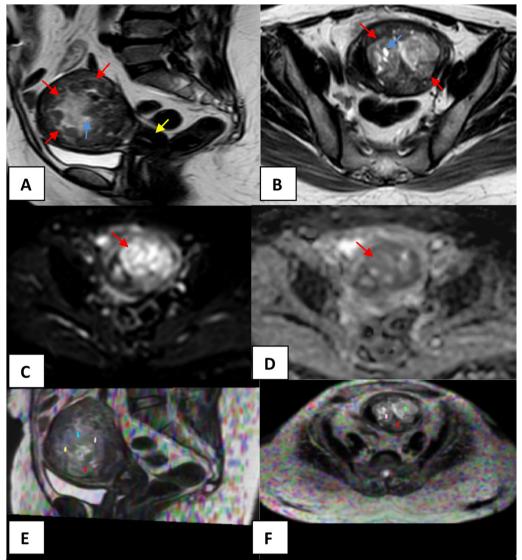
A 51-year-old postmenopausal female presented by menorrhagia and pelvic pain. A, B *Sagittal and axial T2 WIs* occupation of the endometrial cavity by a poorly defined large oval-shaped polypoidal soft-tissue mass displaying heterogeneous SI and infiltrating the uterine body (red arrow). The mass has foci of high SI due to necrosis (blue arrow). No cervical extension (red arrow). C *Axial DWI with b value of 1000 s/mm*² high SI of the endometrial soft-tissue mass (yellow arrow). D *Axial DW-ADC map image* low signal intensity of the endometrial soft-tissue mass (red arrow). Mean DW-ADC value of the mass = 0.898×10^{-3} mm²/s. Mean DW-ADC values at areas of intact and infiltrated myometrium = 1.104 and 0.912×10^{-3} mm²/s, respectively. E, F *Sagittal and axial DTI map images* values of DT-FA and DT-MD in multiple ROI. Mean DT-FA and DT-MD values of the endometrial mass = 0.143 and 0.415×10^{-3} mm²/s, respectively. Mean DT-FA and DT-MD values at areas of infiltrated myometrium = 0.146 and 0.478×10^{-3} mm²/s, respectively. Mean DT-FA and DT-MD values at areas of infaltrated myometrium = 0.146 and 0.478×10^{-3} mm²/s, respectively. Mean DT-FA and DT-MD values at areas of infaltrated myometrium = 0.146 and 0.478×10^{-3} mm²/s, respectively. Mean DT-FA and DT-MD values at areas of infaltrated myometrium = 0.389 and 0.252×10^{-3} mm²/s, respectively. *Diagnosis* Pathologically proved endometrial stromal sarcoma
